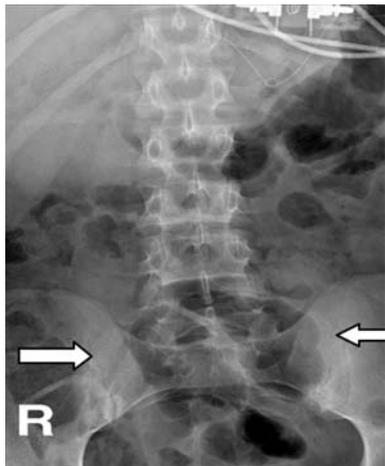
Frontal radiograph shows bilateral sacroiliac joint erosions and iliac side subchondral sclerosis (arrows).
